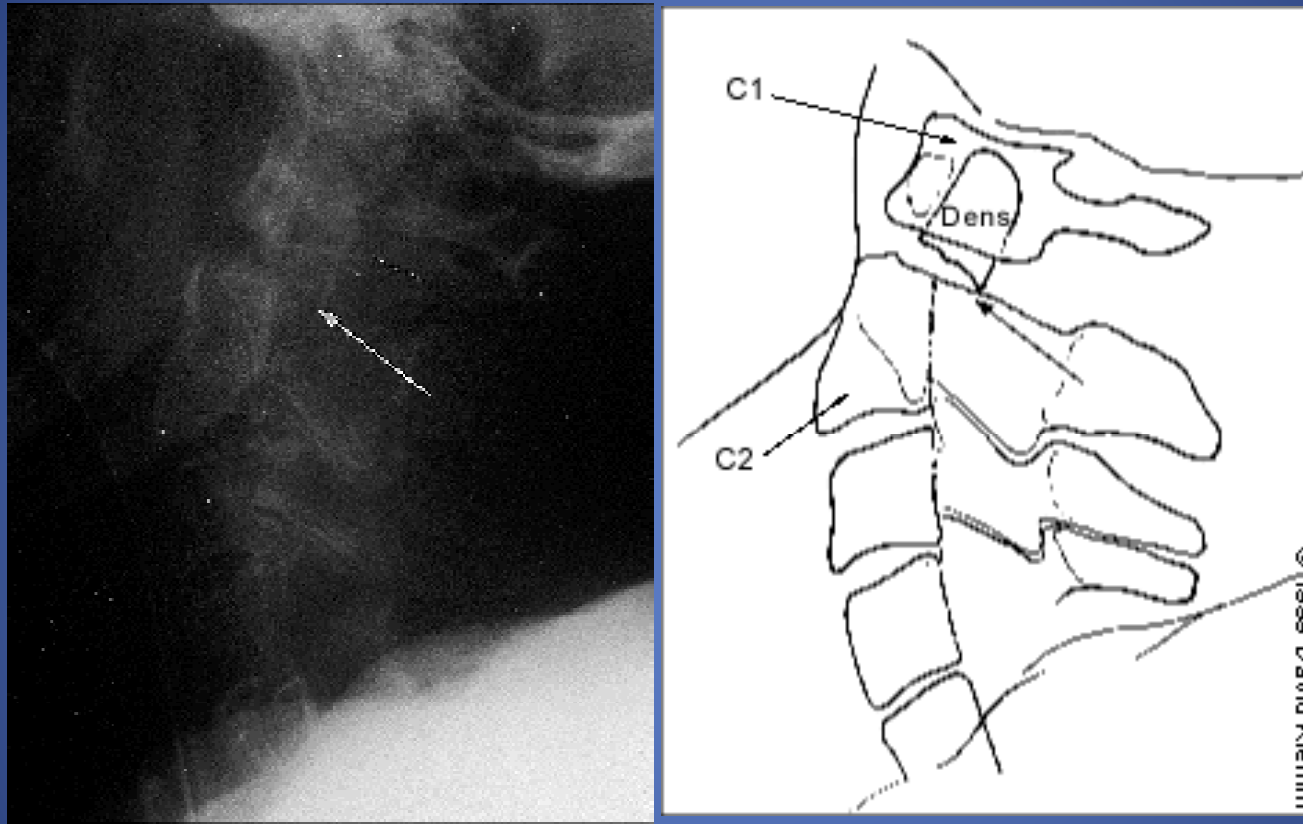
A type II dens fracture. Lateral radiograph shows a fracture through the base of the odontoid process (dens) with the dens and C1 posterior to C2 (*arrow indicates fractured base of dens*).
